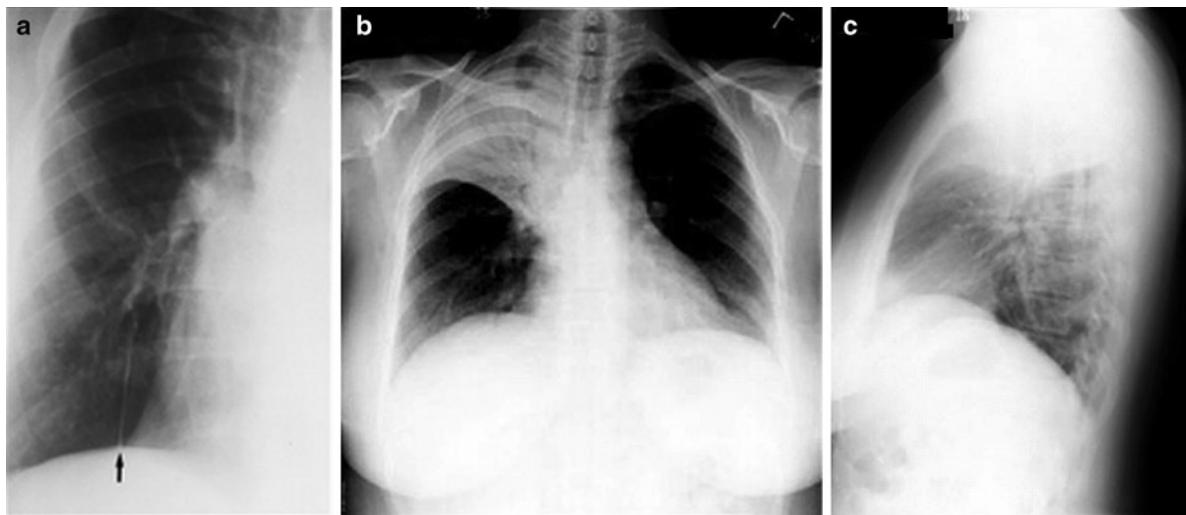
(a) A patient who had a right upper lobectomy showing a thin juxtaparenchymal peak demonstrated by *an arrow*. (b) A right upper lobectomy without the juxtaparenchymal line. (c) Lateral chest radiograph of the same patient.
